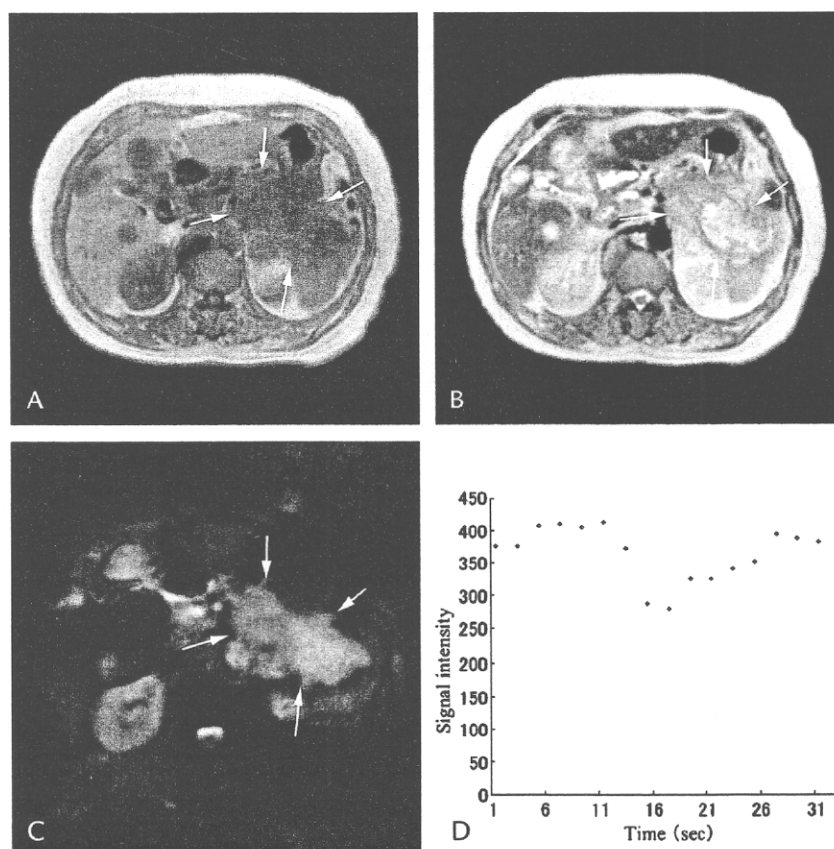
Perfusion-weighted MRI (with negative enhancement) showing high SR in a 63-year-old woman with advanced pancreatic body cancer. A, T1-weighted fast gradient echo image (187/4). B, T2-weighted fast spin echo image (3150/10). C, perfusion-weighted MR pre-contrast image. D, the time intensity curve of SR. These MR images show an irregular tumor in the pancreatic body (A, B, C, arrows). The time intensity curve (D) shows a large signal drop. The SR was 33%.
